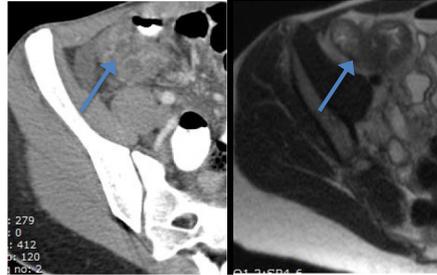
Imaging examples of evaluated findings on CT and MRI.
